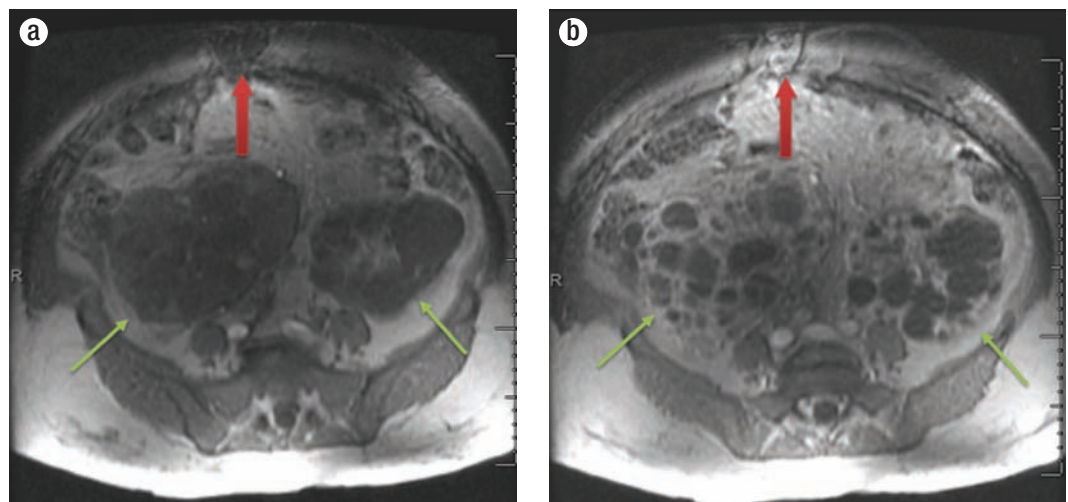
(a) Precontrast and (b) postcontrast transaxial spoiled gradient echo MR images from November 2005, which depict an enhancing anterior periumbilical mass that was biopsied in September 2014 and proven to be epithelial-type peritoneal mesothelioma (red arrow). Changes of polycystic kidney disease are also shown in these images (green arrows).
